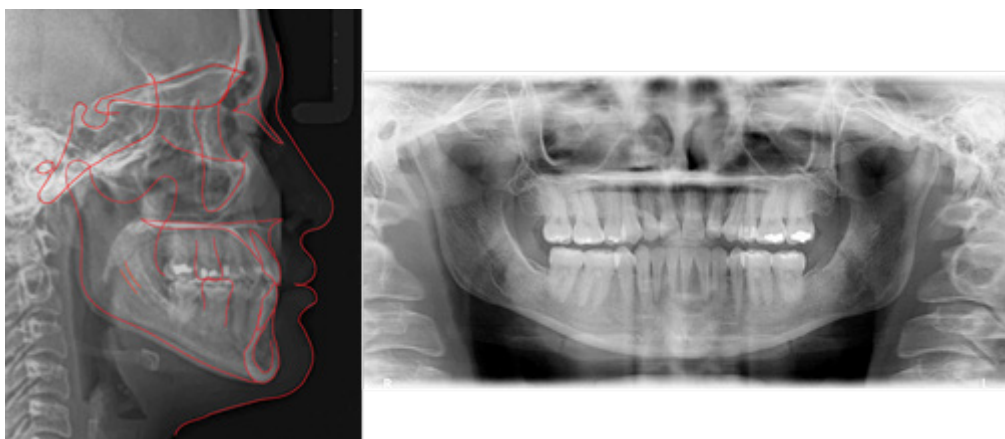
Cephalometric radiograph with tracing and panoramic radiograph at the end of treatment.
